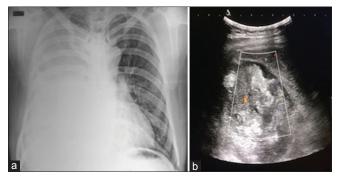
(a) Chest radiograph showing a large, homogeneous radiopacity involving the right hemithorax with an associated mild mediastinal shift to the left side. (b) Ultrasound with color Doppler of the right hemithorax showing a heterogeneous hyperechoic mass lesion with areas of color flow within the mass
